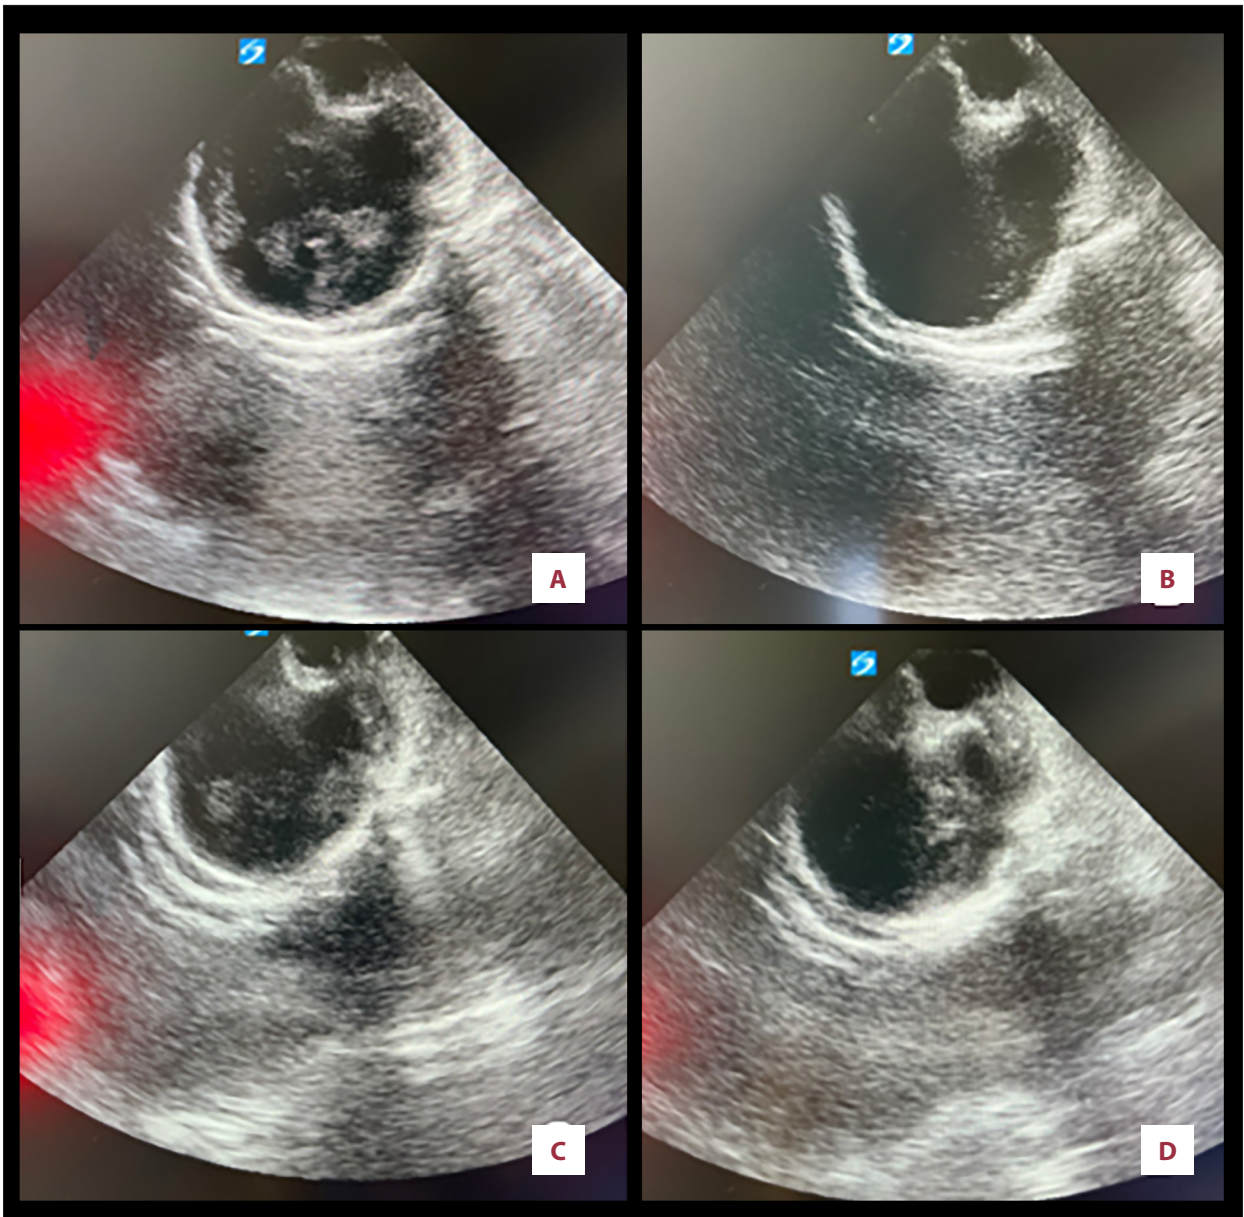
B-scan ultrasonography of the right eye demonstrating intravitreal condensations and distorted globe architecture (A, B), and of the left eye demonstrating intravitreal condensations (C, D).
